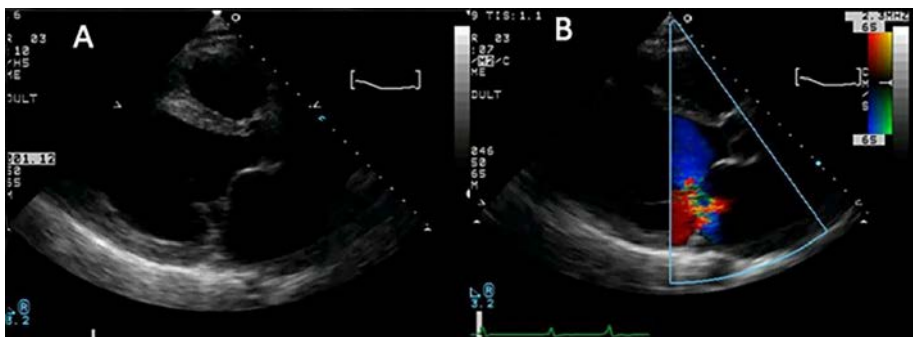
2-D and colour Doppler echocardiography to evaluate complications in acute STEMI. 2-D echocardiography shows (A) a flail mitral valve prolapsing into the left atrium with (B) severe eccentric mitral regurgitation.
